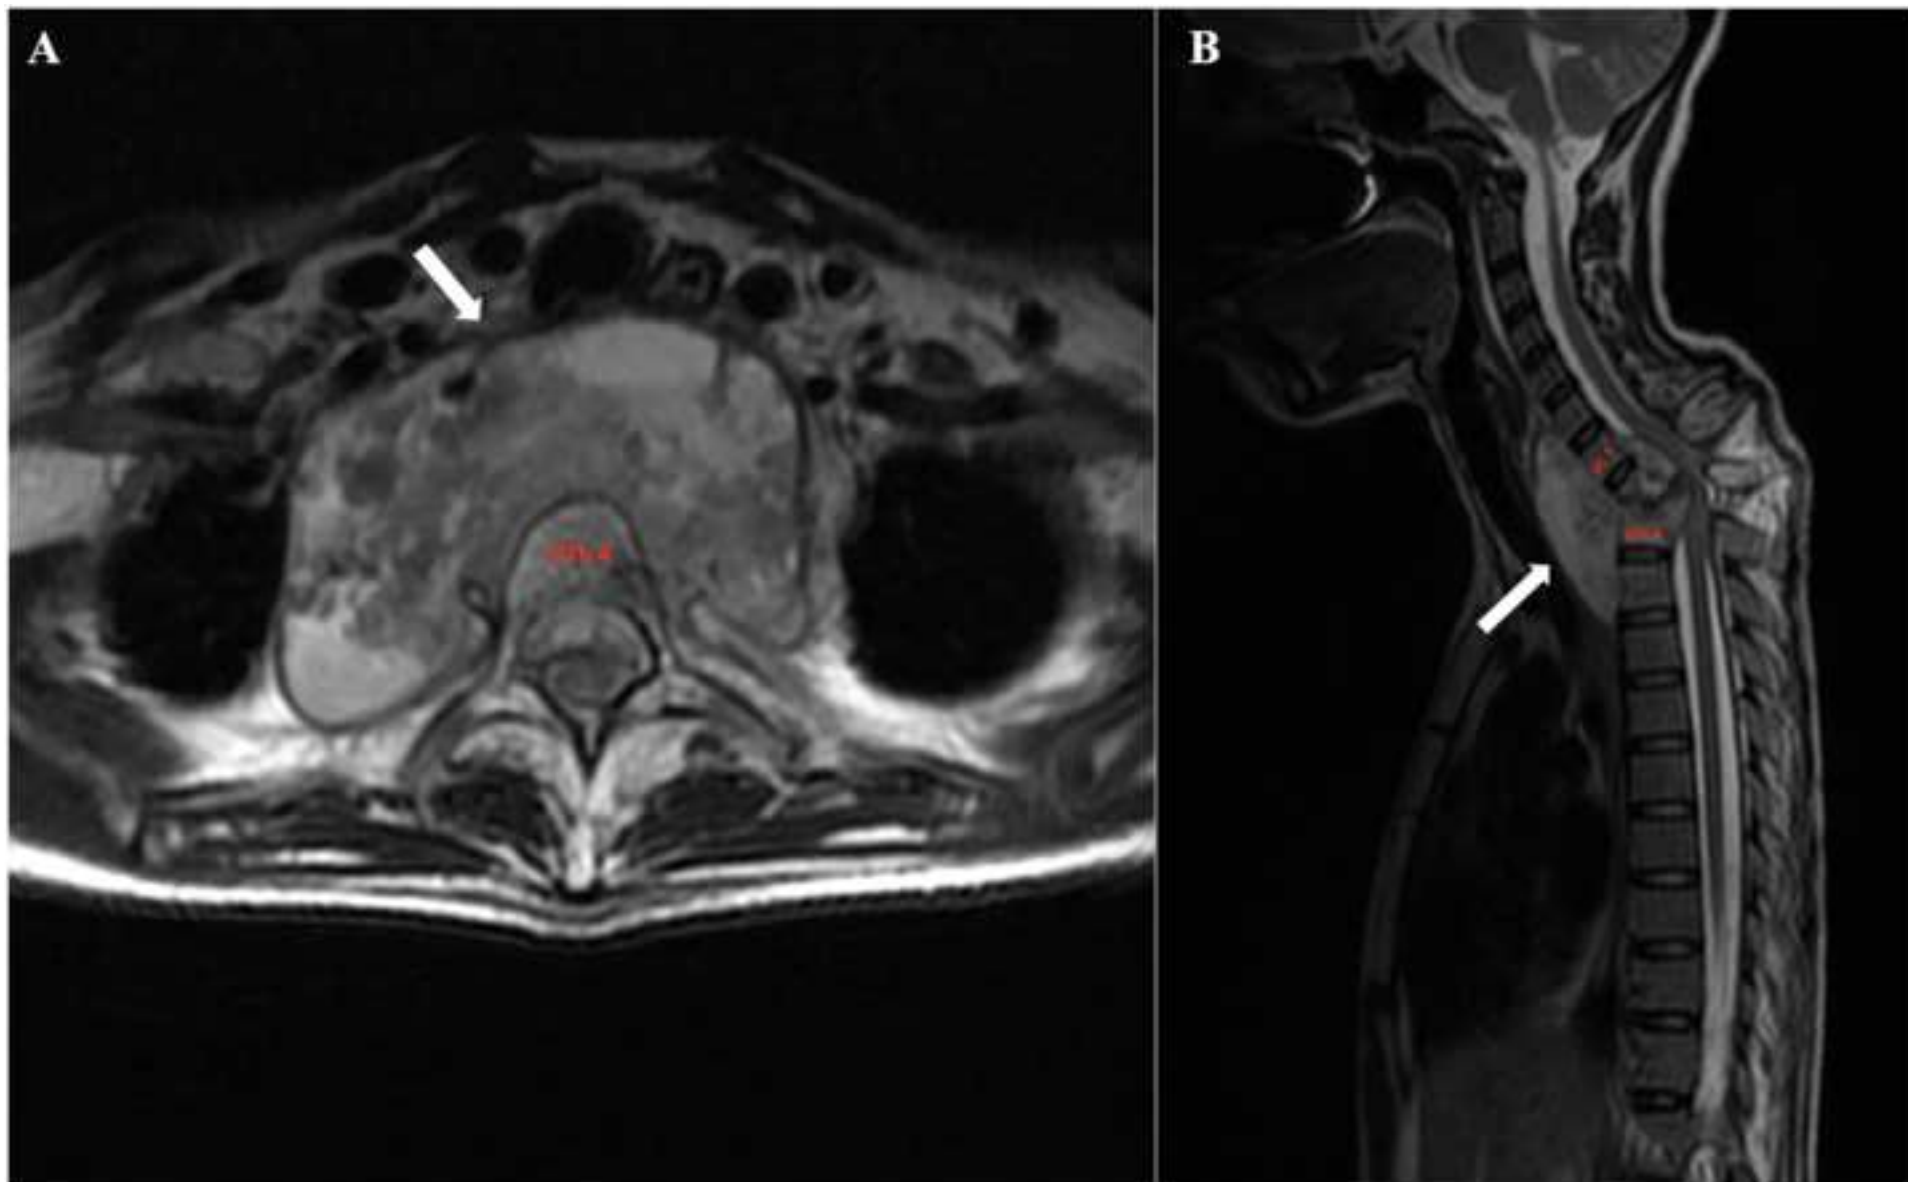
MR imaging of axial (A) at the level vertebral T3 and sagittal (B) views showed a large paravertebral abscess (↑) in the anterior of the level vertebral C5 to T3. In the sagittal view (B), vertebral body destruction and spinal cord compression at the level of vertebral T1 to T3.
